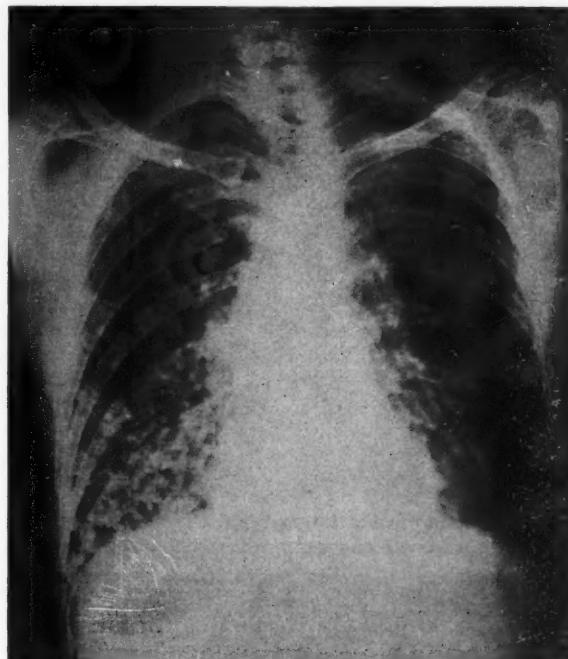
Chest roentgenogram of Case 1, H. L., one month after onset of symptoms.
